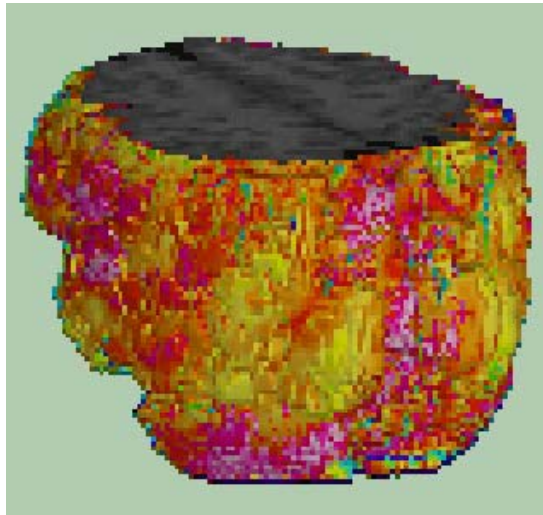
The same data as in Figure 3.4. The APG method was used to map the activated areas onto the surface of segmented MRI of the same patient. See page 68 for a colour version of the figure.
